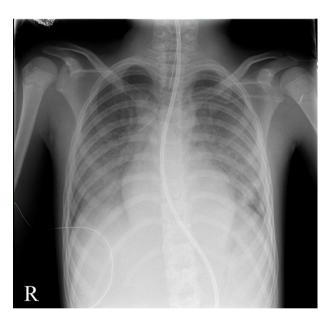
Chest X-ray on day 3: bilateral pulmonary infiltrates.
